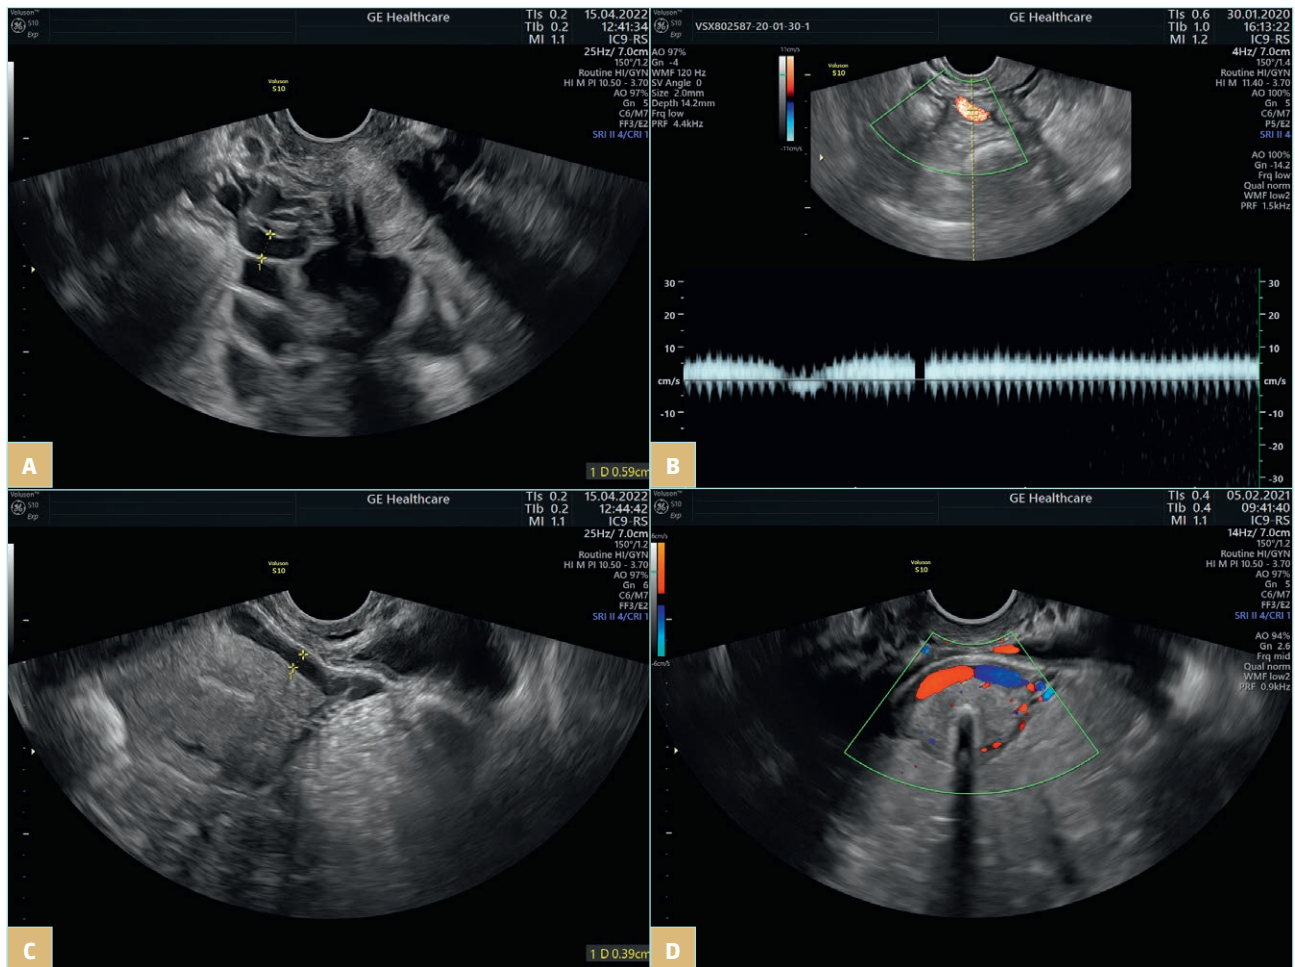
Transvaginal ultrasonography of a patient with a pelvic venous disorder. A) Pelvic varicocele. B) Venous reflux in periuterine venous plexus. C-D) An arcuate vein crossing the uterine body.
